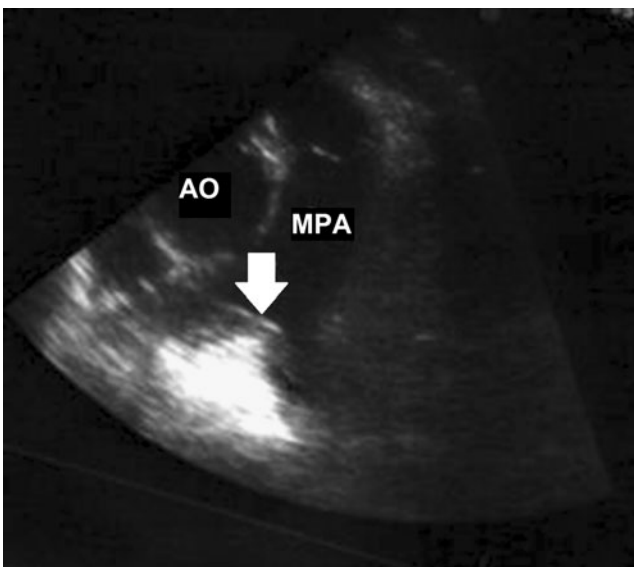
Parasternal short axis echocardiographic view: MPA = Main Pulmonary Artery; AO = Aorta; Arrow indicates saddle pulmonary embolus at the pulmonary artery bifurcation
